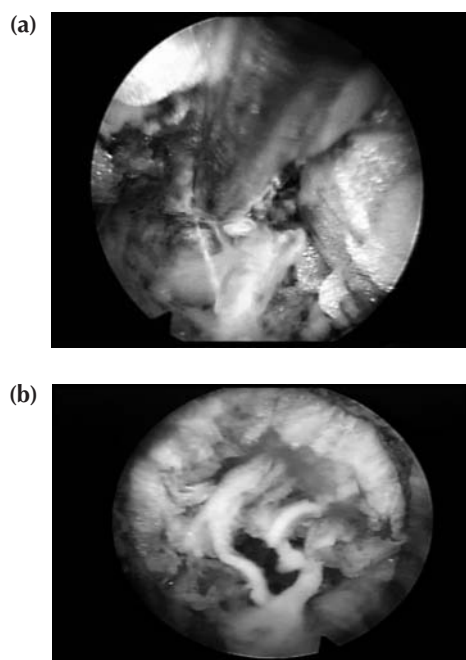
Anomalous nerves. (a) Anomalous nerve identified in the annular fat in the foramen. When found in the foramen, it is considered an anomalous branch, but furcal nerves are common branches from the exiting nerve entering the psoas muscle. These communicating branches are described as furcal nerves in the anatomy and literature. Small sympathetic nerves are occasionally seen. (b) Neo-angiogenesis and neo-neurogenesis are commonly present in the inflammatory membrane adjacent to annular tears in patients who have severe discogenic pain and sciatica, but a rather benign MRI.
